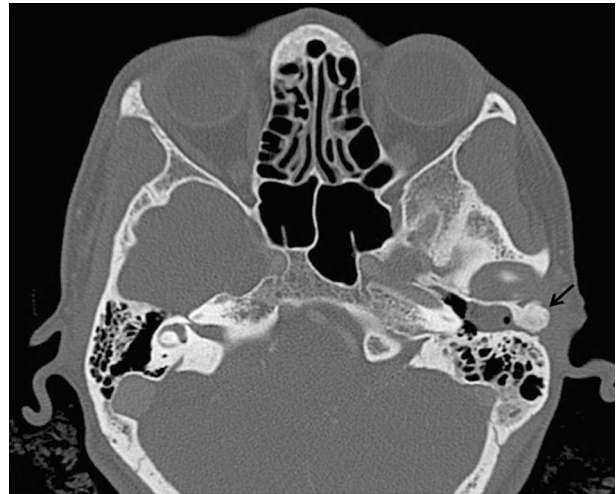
Bushing in the left external ear and 10 mm diameter bone lesion with equivalent density to bone in the antero-superior bone structure section opening to the external ear canal and showing continuity, were observed on the axial temporal bone CT image.
